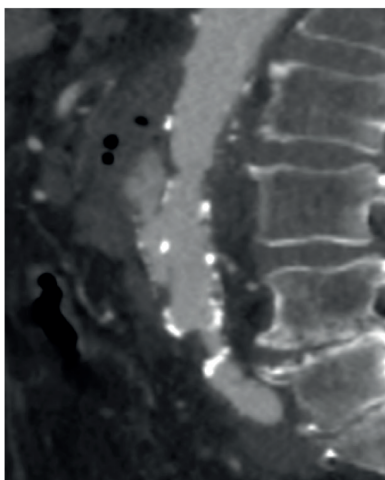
Computed tomography (CT) of a contained ruptured mycotic aneurysm with a polilobulated morphology and periaortic gas.
